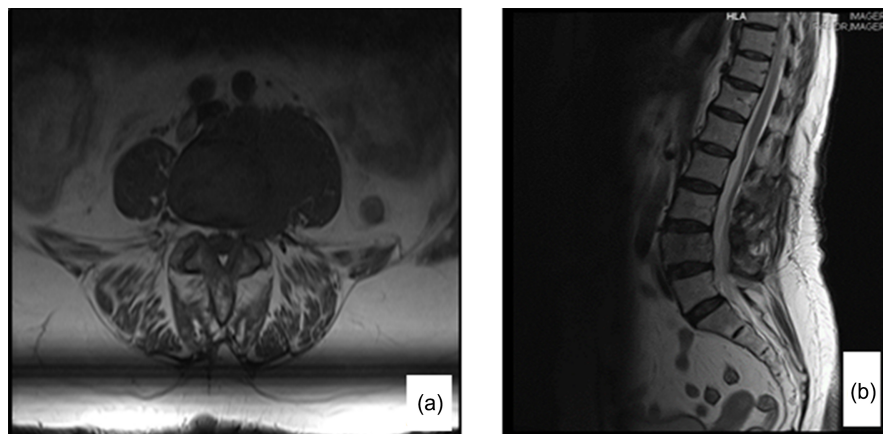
MRI lytic image bone Lumbar L4 chordoma. (a) Transversal view; (b) Lateral view.
